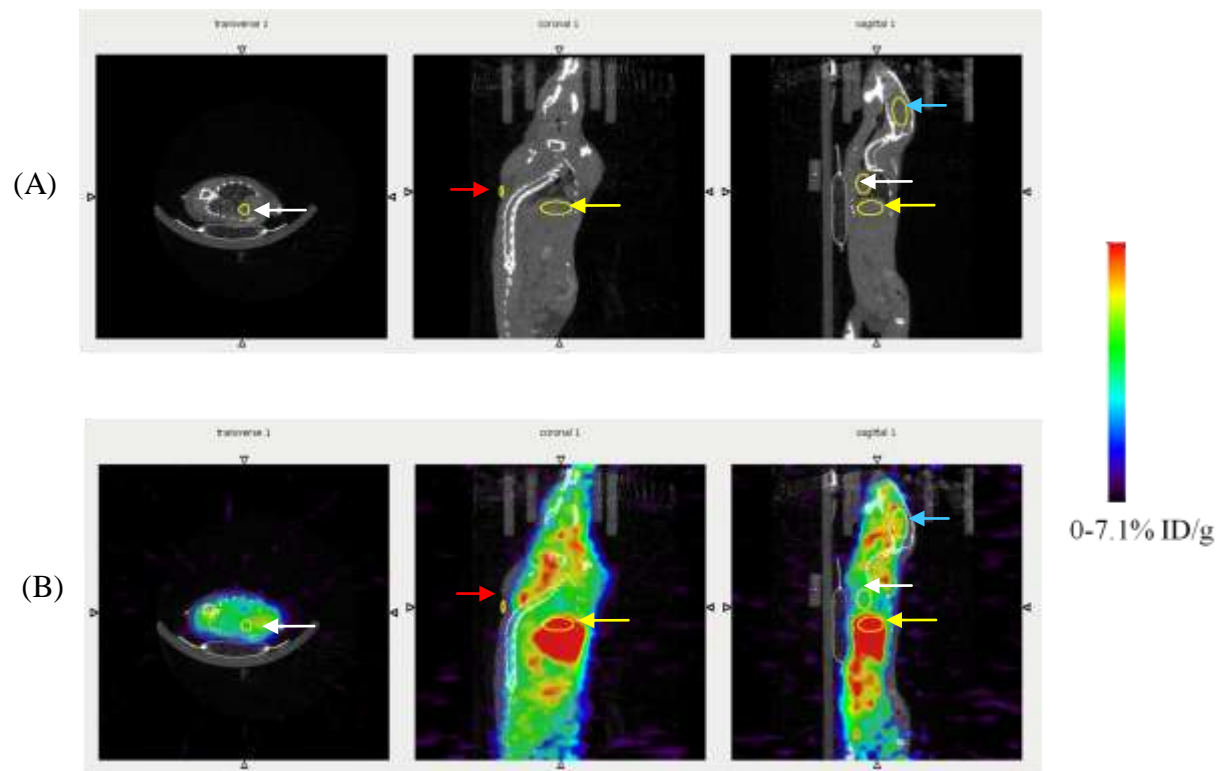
Dynamic PET image 12-14 minutes pi: ROIs for tumour (coronal view, red arrow), brain (sagittal view, blue arrow), heart (transverse and sagittal view, white arrow) and liver (coronal and sagittal views, yellow arrow). (A) CT image (B) PET/CT image. PET calibration bar indicating 0-7.1% ID/g
